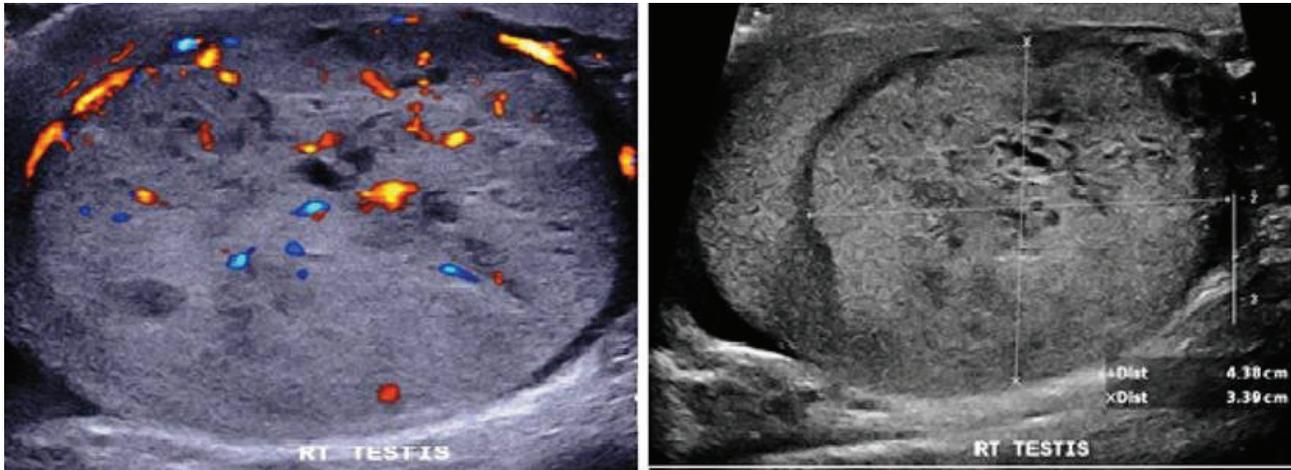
and Figure 2: Color Doppler ultrasonography of right Testis showed hypoechoic mass in the right testis with internal vascularization.
